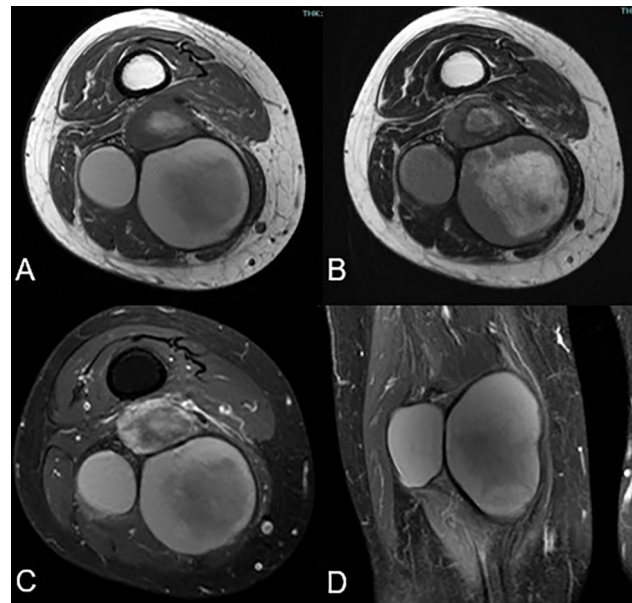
MRI showing T1-weighted (A), T2-weighted (B), and enhanced T1-weighted (C,D) images with heterogeneous signal and hemorrhagic features. MRI: Magnetic resonance imaging.
